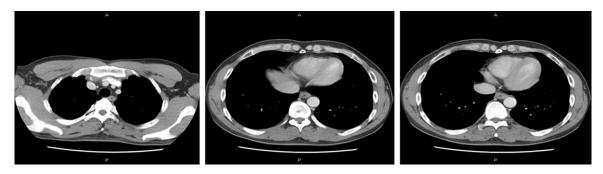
Chest CT scan showed that the esophageal wall is slightly thickened.
